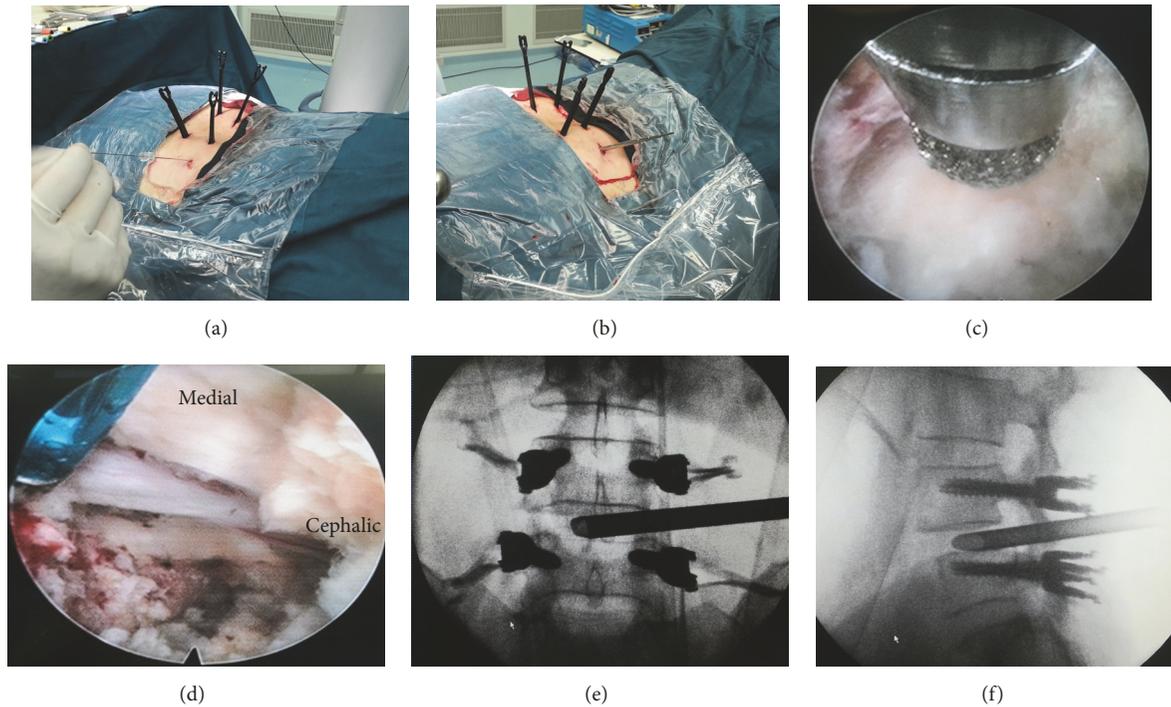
(a) Percutaneous transforaminal puncture into disk after percutaneous pedicle screw fixation. (b) Sequential dilation. (c) Optional foraminoplasty and expansion of the safety triangle by bone drill under endoscopic views. (d) Neurological decompression and initial endplate preparation in endoscopic view. (e) and (f) Working tube insertion in anteroposterior and lateral X-ray views.
